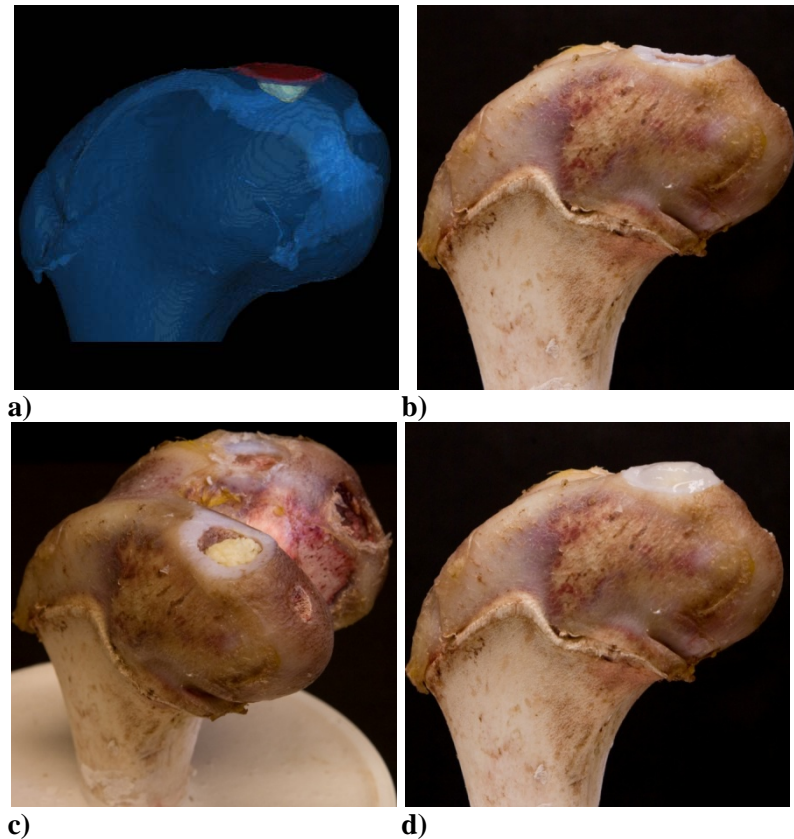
Repair of the osteochondral defect. (a) CT scan of the femur and the two-material osteochondral defect. The cartilage portion of the defect is highlighted in red and the bone portion in yellow. (b) Unrepaired osteochondral defect. (c) Partially repaired osteochondral defect where the bone portion has been printed. (d) Fully repaired osteochondral defect where the hydrogel is visible and the DBM lays beneath.
